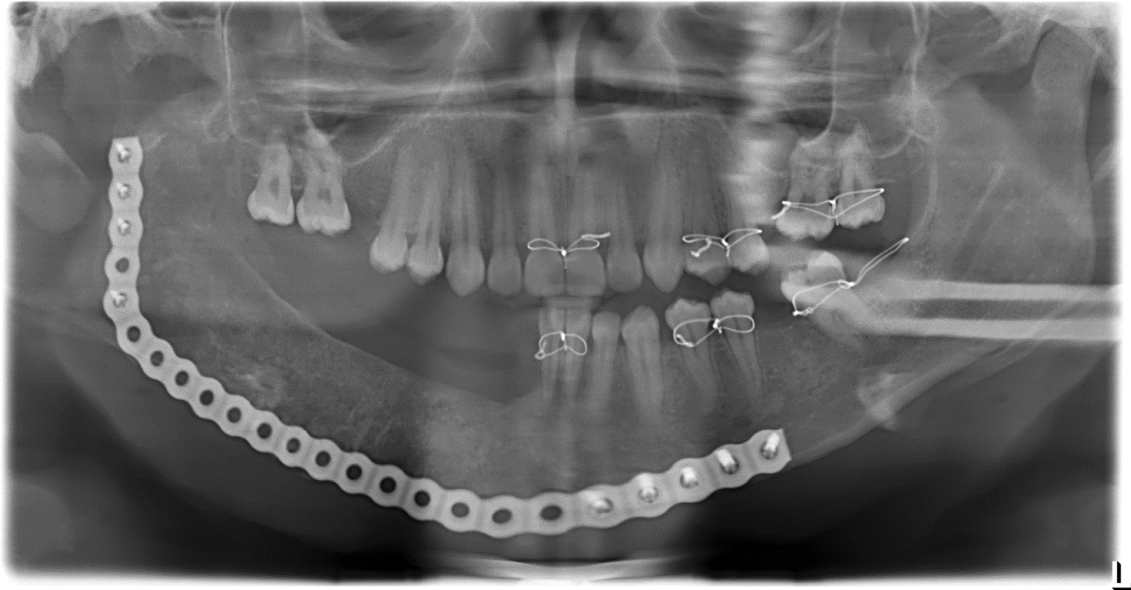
Panoramic radiographic showing regenerated bone 3 months post-grafting.
